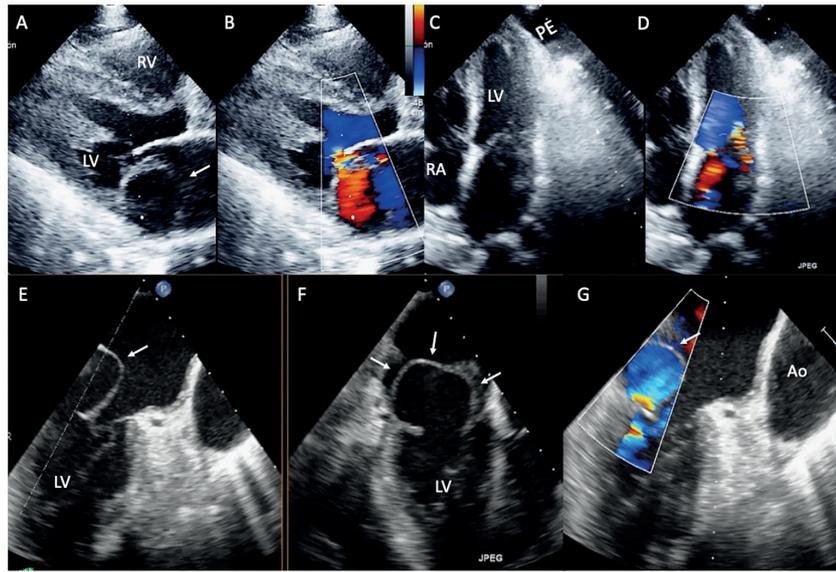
Transthoracic 2D Doppler echocardiography in the parasternal long axis view showing a cyst-like thin-walled atrium (A) and moderate mitral regurgitation (B). In the apical chamber a left pleural effusion (C) and also a moderate mitral regurgitation (D) were visualized. Transoesophageal 2D images at 60° and 90° (E-F) confirmed the presence of a heterogeneous cyst-like mass (white arrows) in the left atrium involving the posterior mitral annulus. The color Doppler revealed a blood flow to this cavity (G). LV: left ventricle; LA: left atrium; RA: right atrium; RV: right ventricle; Ao: aorta; PE: pleural effusion.
